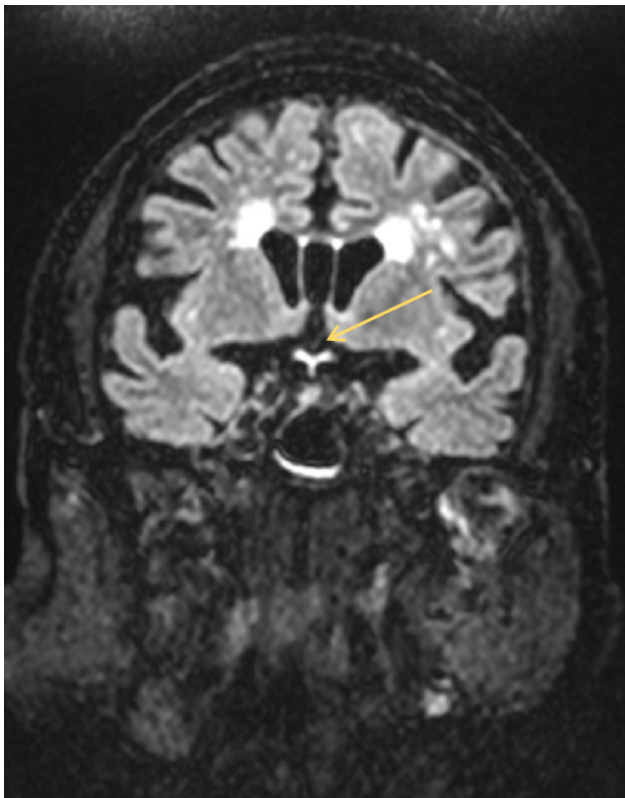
Coronal view of MRI FLAIR sequence showing enhancement of the optic chiasm (arrow)
